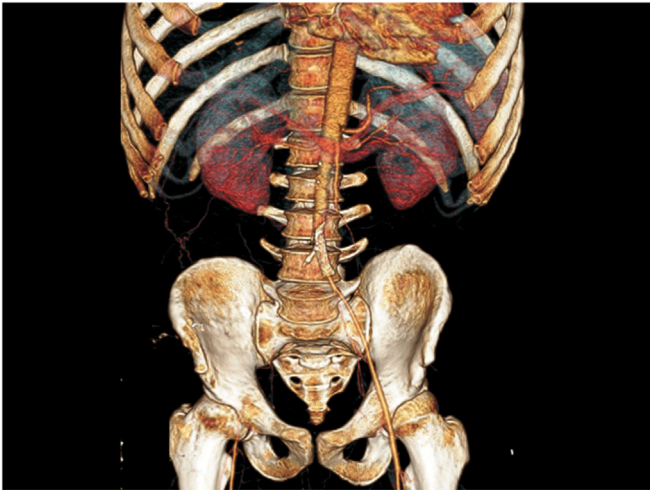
Computed tomography angiogram demonstrating aortic occlusive disease with aortic tapering and TASC (Trans-Atlantic Inter-Society Consensus) class D right iliac artery lesion with a stent impinging on the orifice of the right iliac artery and left iliac artery narrowing.
